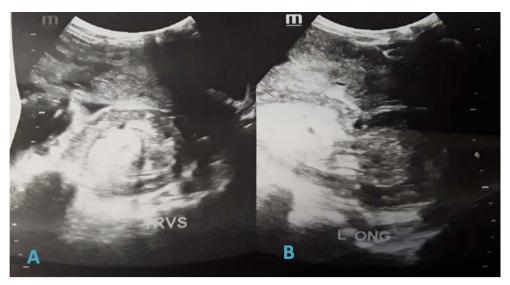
Abdominal ultrasound showing A) "target sign" in transverse section and B) "pseudo-kidney sign" in longitudinal section.
